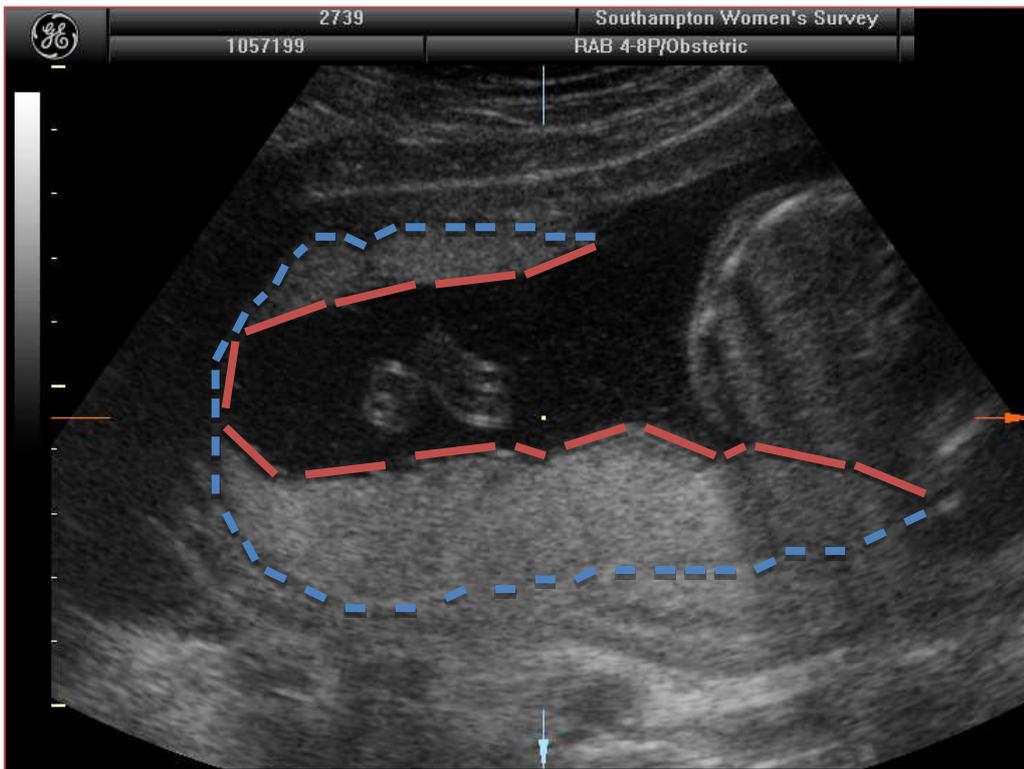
A 19 week ultrasound scan showing placental size measurements in the longitudinal plane
